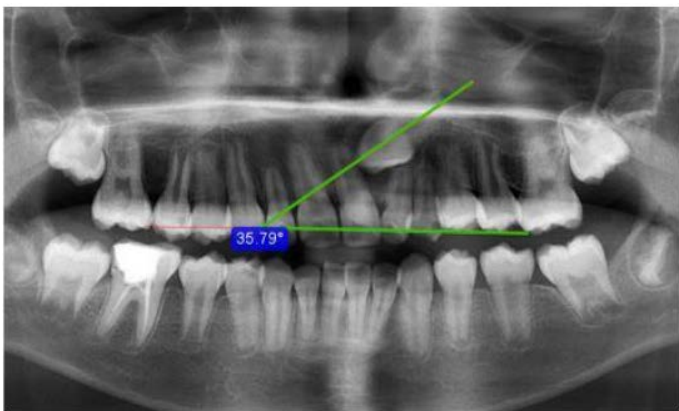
Panoramic radiograph showing localisation with angular method
